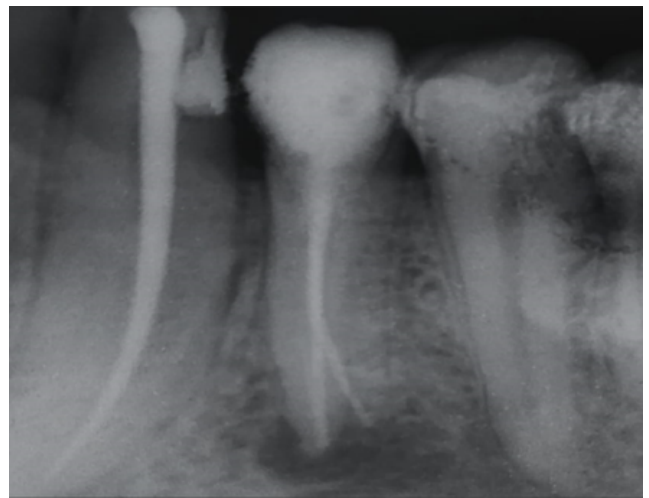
Periapical healing after 6 months
